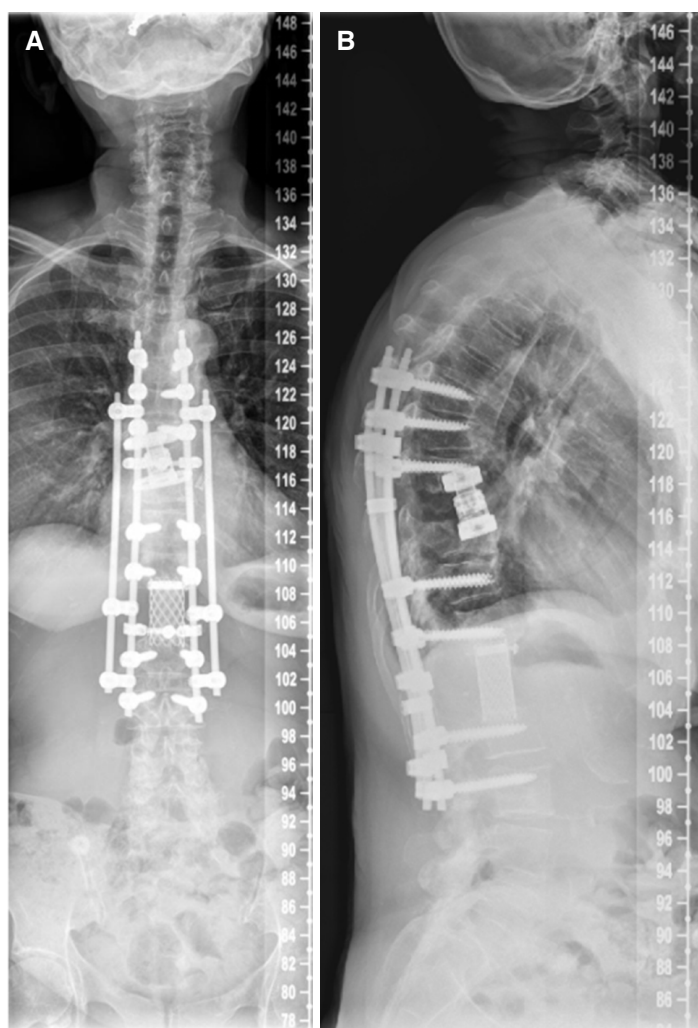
Two plane full spine radiographs of a 65 year old female patient with metastatic breast cancer(A, B). En-bloc spondylectomy in Tomita technique at the Th9 and L1 level with a time interval of 10 years. Anterior in situ distractible cage at the Th9 level and Harms cage at the L1 level, posterior 4-rod instrumentation Th6-L3
